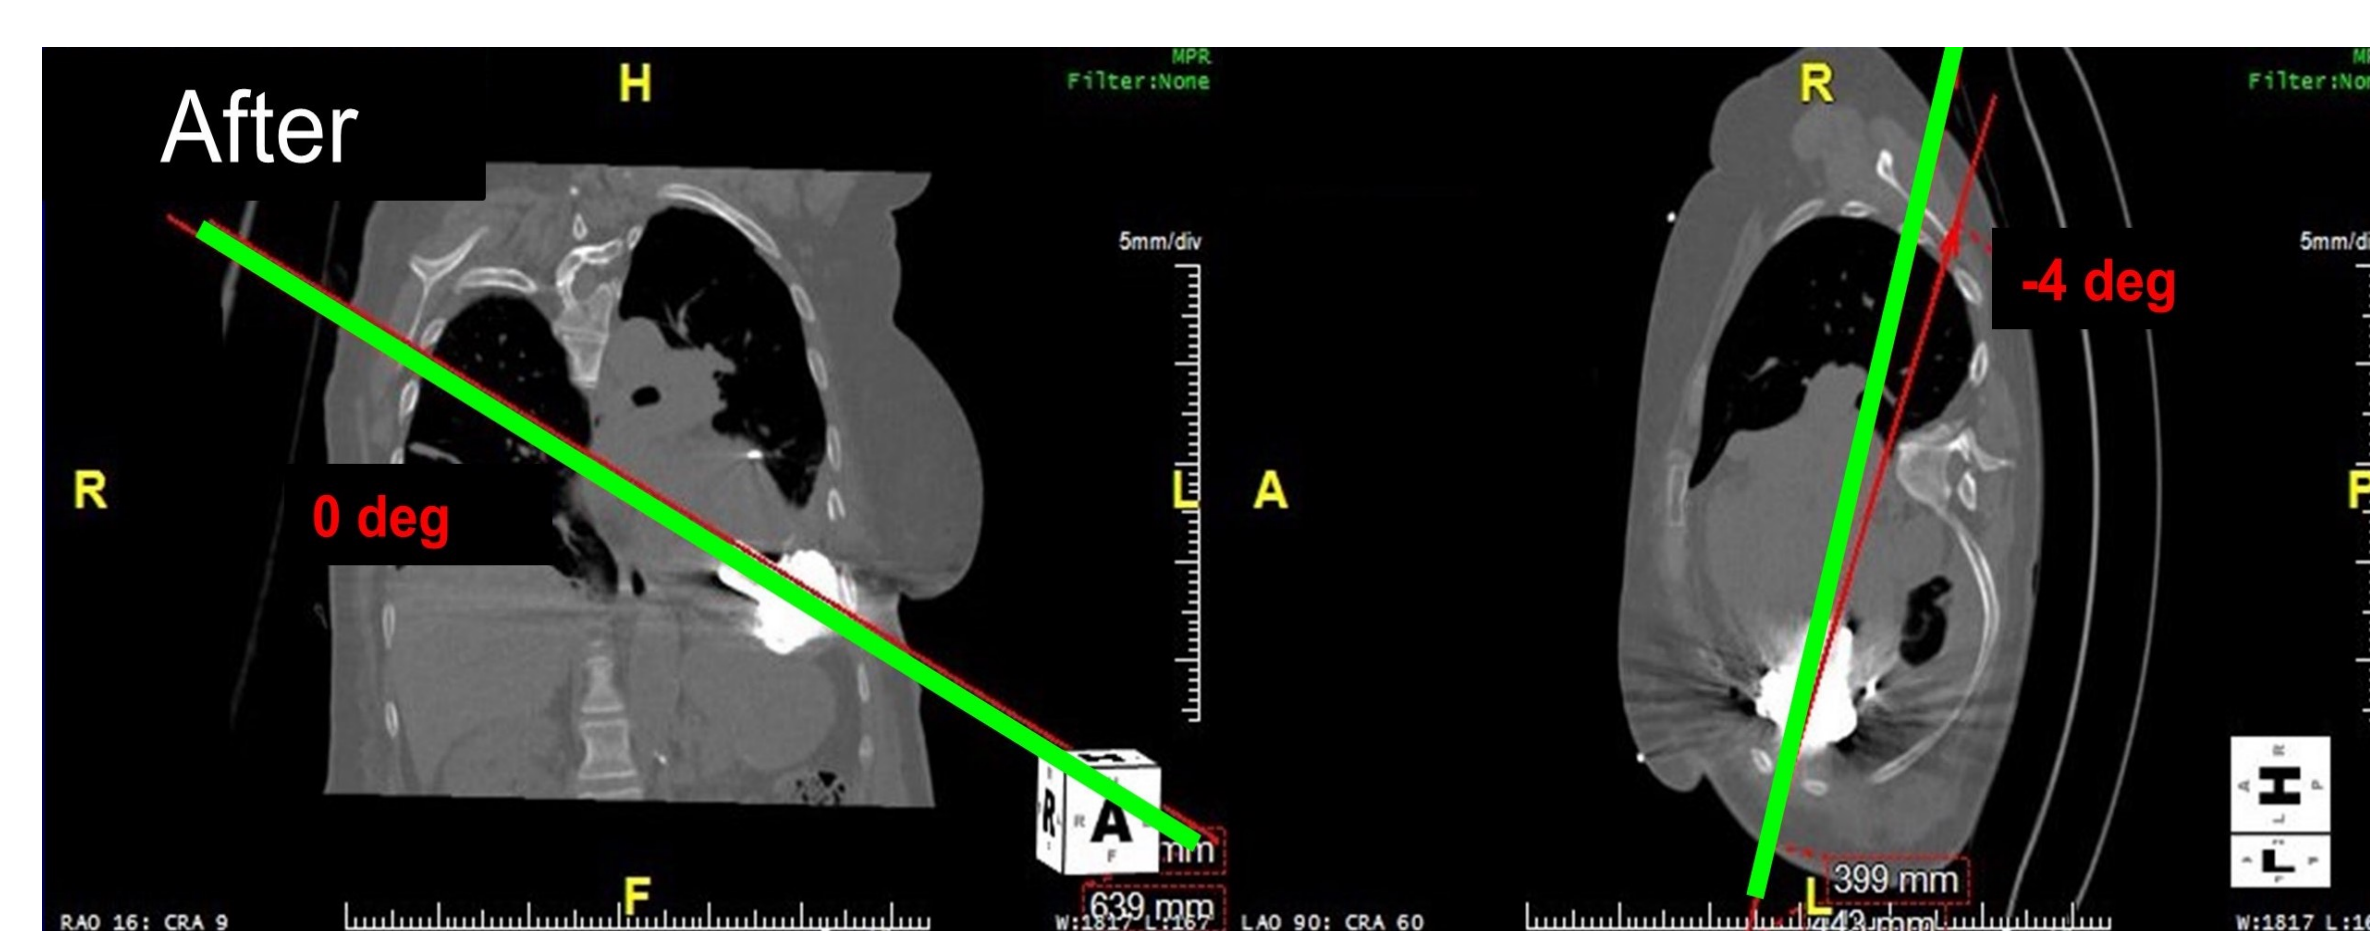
CT scans demonstrating correction of the angular deviation, with perfect alignment with the ideal line in the coronal plane (0 degrees deviation) and only mild deviation in the sagittal plane (4 degrees)
